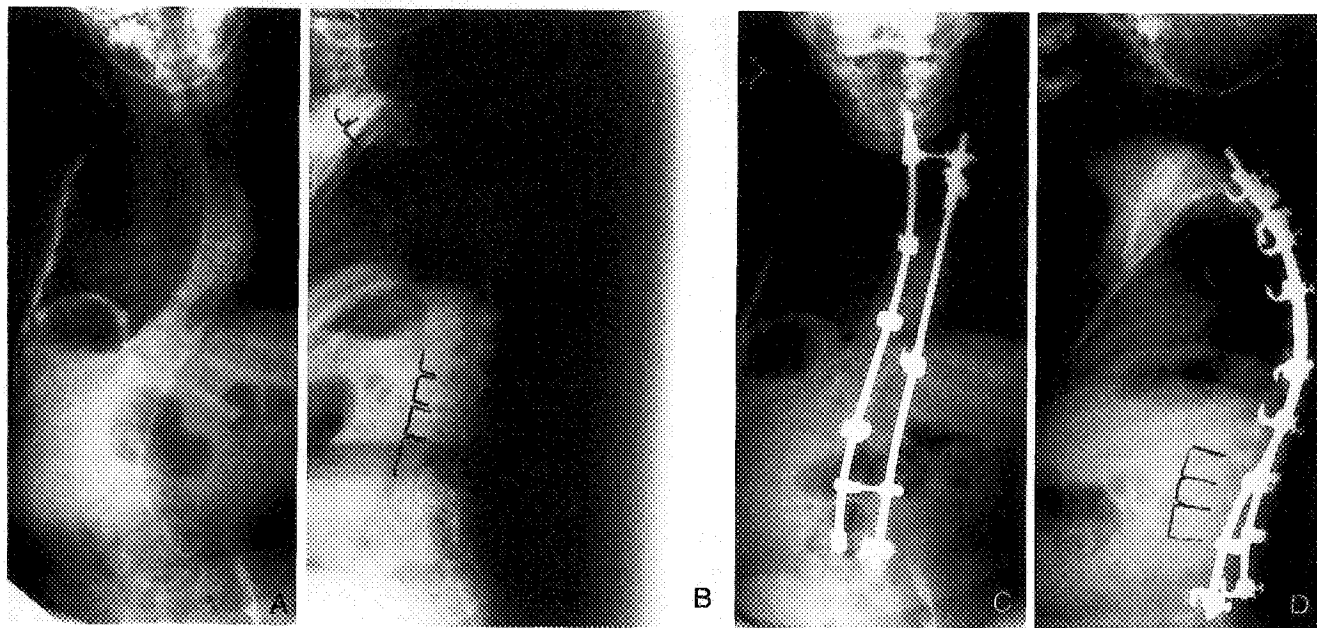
(A) Preoperative AP and (B) lateral radiographs of a double major curve pattern and upper thoracic kyphosis. (C) AP and (D) lateral postoperative radiographs. The patient underwent Cotrel-Dubousset instrumentation without fusion due to her young age. The curve has continued to progress despite instrumentation.
